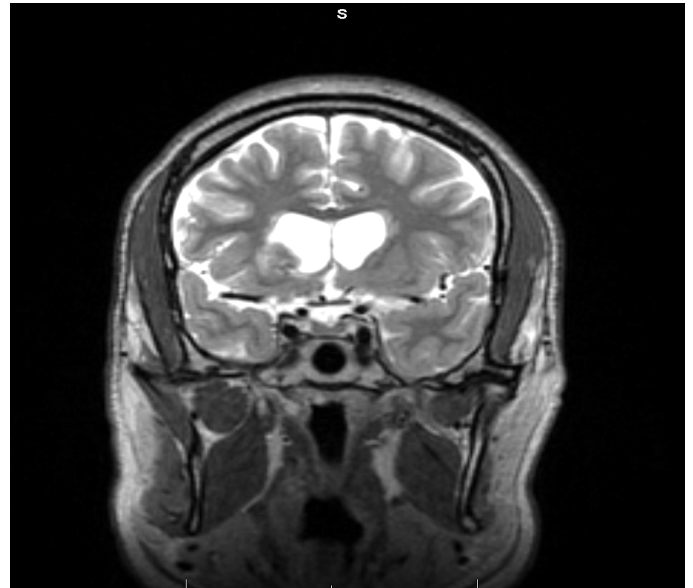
Brain MRI Post treatment with WBRT (T2 coronal image) showing abnormal signal changes in right caudate nucleus and periventricular white matter are markedly improved after the treatment.
